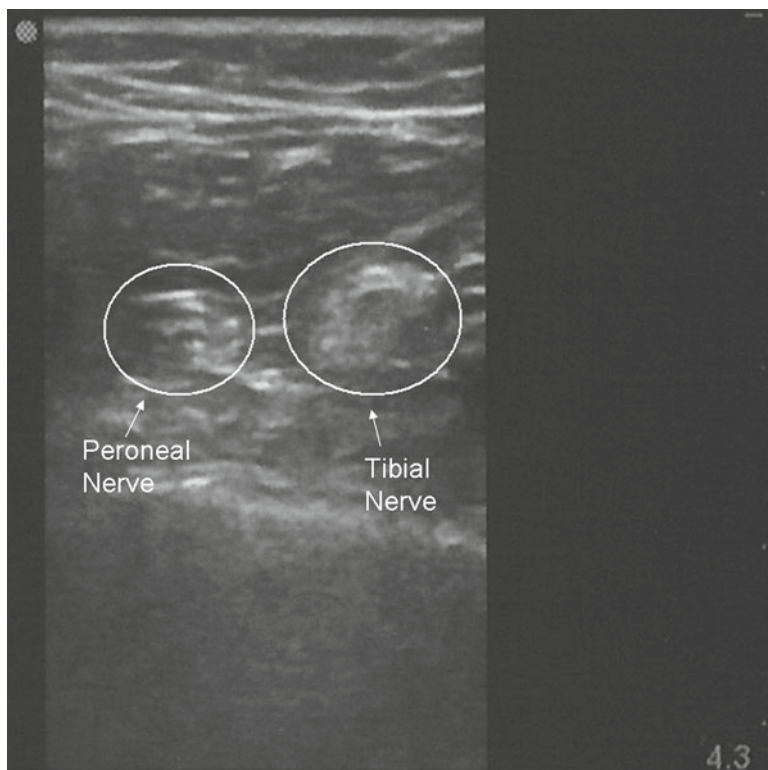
Ultrasound-guided popliteal approach. The common peroneal nerve (lateral) and tibial nerve (medial) are identified in close approximation (*left* is lateral and *right* is medial)
